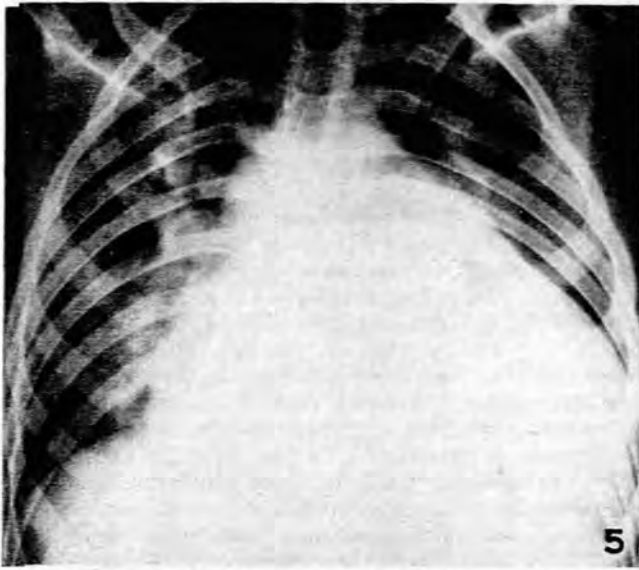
X-ray of chest 16 February 1957, showing gross cardiomegaly and extreme pulmonary plethora and dilatation of all chambers of the heart.
